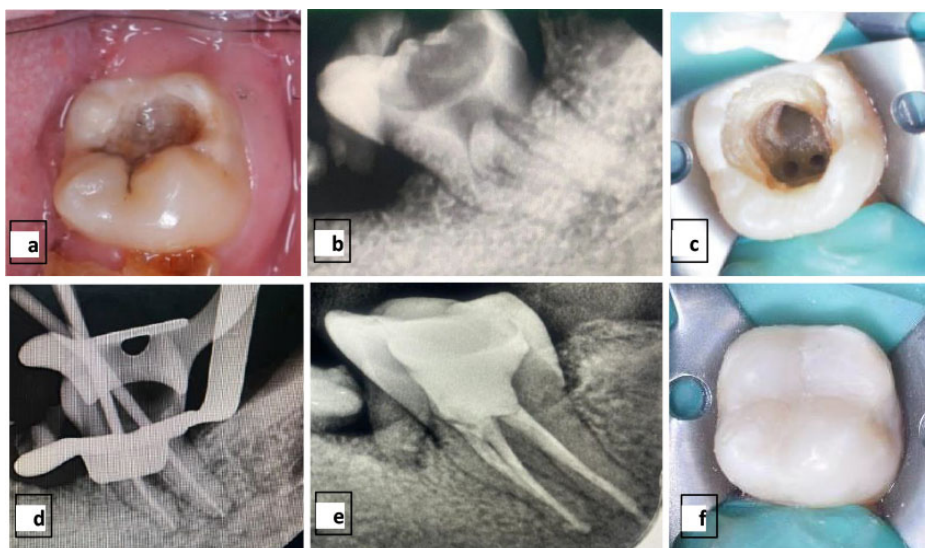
(a) and (b) Pre-operative. (c) Biochemical preparation. (d) Gutta-percha master point radiograph. (e) and (f) Post-operative.
